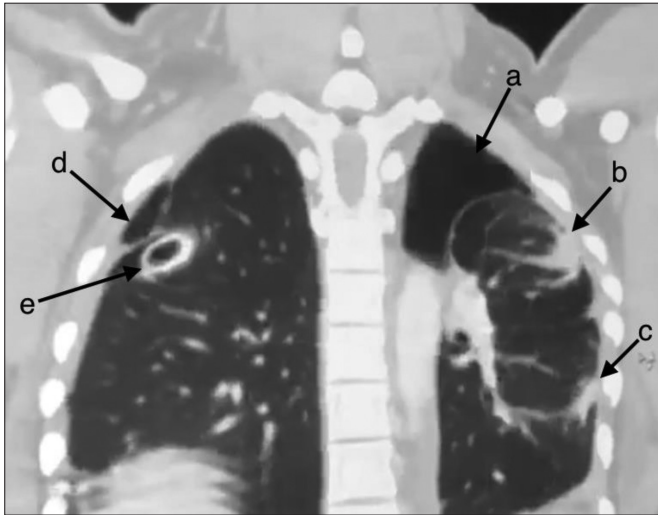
Computed tomography scan after the patient's second presentation. (A) left haemopneumothorax; (B) round atelectasis; (C) round atelectasis; (D) small right haemopneumothorax; (E) right intercostal drain in situ.
